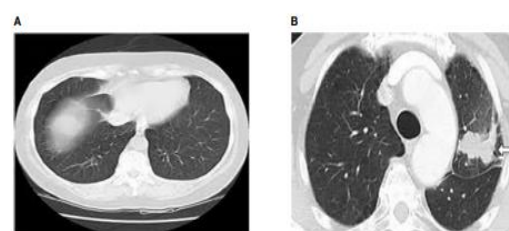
(A) Lung Image (CT) (Normal) (B) Lung Image (CT) (Abnormal). [17]
